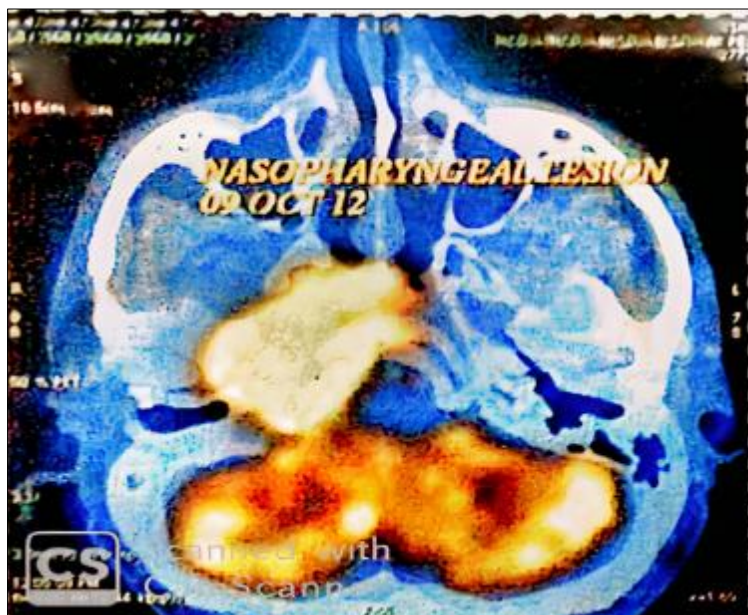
Ca nasopharynx initial disease status on PET-CT
